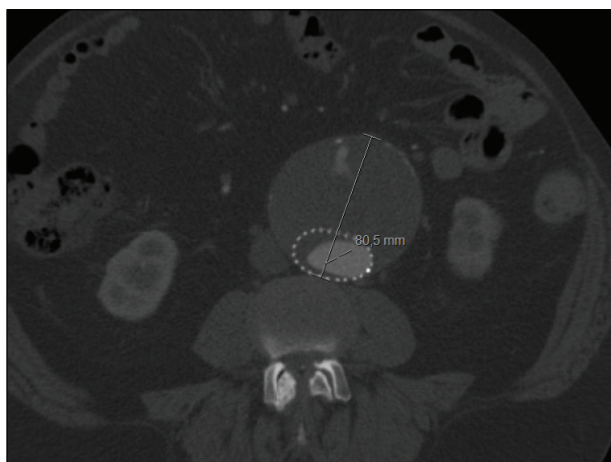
CTA of the Case 1 patient showing the infrarenal abdominal aneurysm after endovascular aneurysm repair. The diameter of the aneurysm was 80 mm, and there was a type II endoleak through the IMA and the arc of Rioloan. Individual results may vary.
